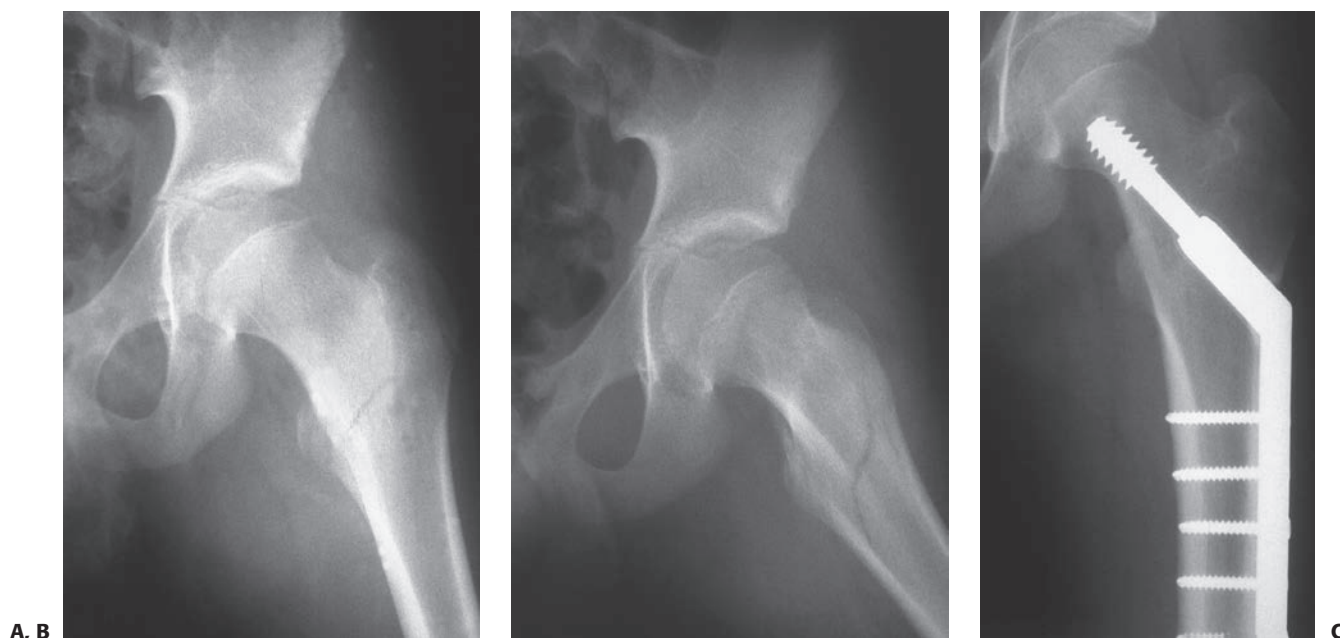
A: A 14-year-old boy who fell from a tree swing sustained this nondisplaced left intertrochanteric hip fracture. B: Lateral radiograph shows the long spiral fracture. C: Three months after fixation with an adult sliding hip screw.
